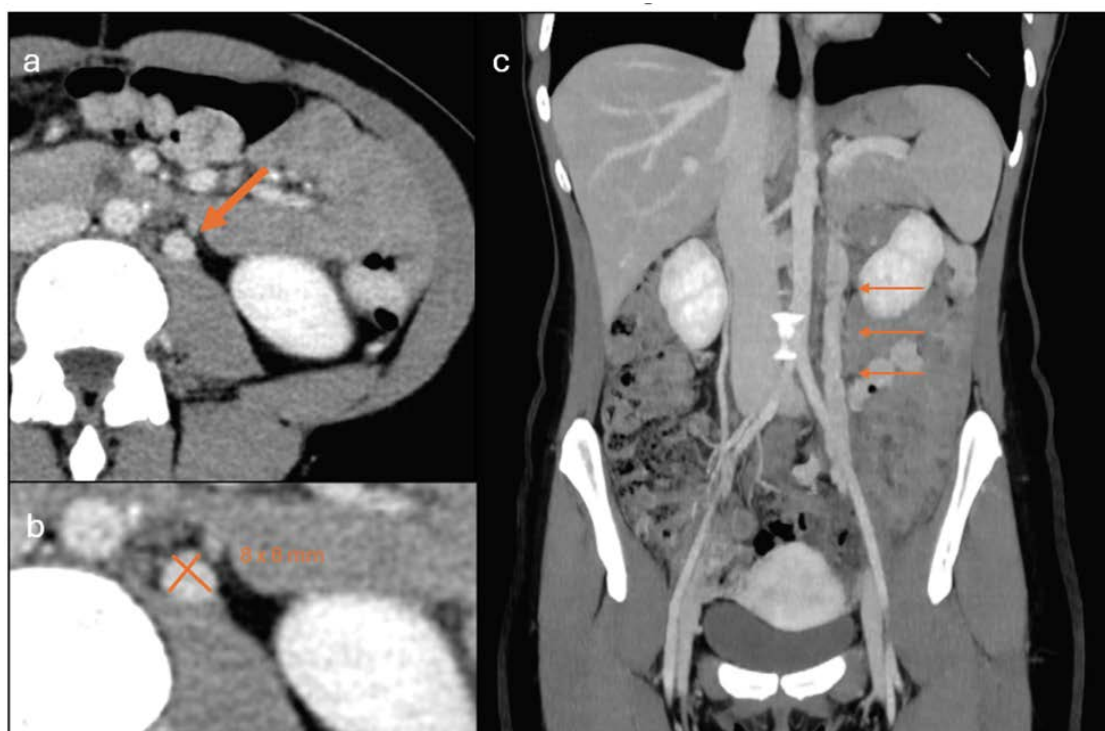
Dilatation of the left ovarian vein : 31-year-old female with pelvic venous congestion secondary to posterior nutcracker syndrome. *Findings:* Axial (*image a*, magnified in *image b*) and coronal (*image c*) portal venous phase contrast-enhanced CT images demonstrate marked dilatation of the left ovarian vein (arrow), measuring up to 8 × 8 mm. This reflects upstream venous stasis as part of pelvic congestion syndrome, due to impaired venous drainage via the retroaortic left renal vein. *Technique:* Axial and coronal CT, 218 mAs, 80 kV, 1.25 mm slice thickness, portal venous phase after intravenous injection of 80 ml of iodinated contrast agent (Iohexol 300 mg I/mL).
